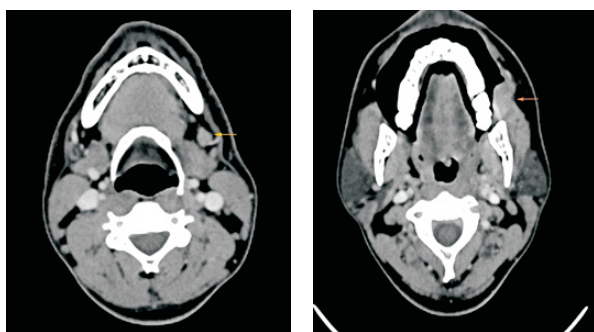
Contrast-enhanced CT shows left level 1B lymph node with loss of fatty hilum (yellow arrow), likely metastatic. Note the carcinoma (orange arrow) in the left buccal mucosa. Reaching up to the retromolar trigone.
